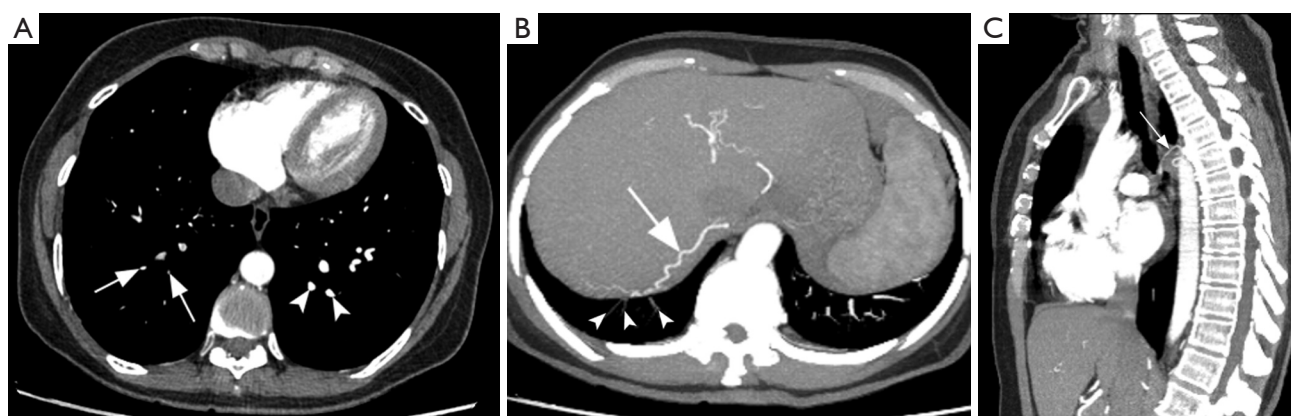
CT pulmonary angiography features of chronic thromboembolic pulmonary hypertension. Axial image (A) showing reduced caliber vessels (arrows) related to the contraction of the organizing thrombus and poor contrast opacification in comparison with contralateral arteries (arrowheads). Axial maximum intensity projection (MIP) at the thoracoabdominal transition (B) showing a prominent phrenic artery (arrow) providing systemic collateral circulation, in addition to asymmetric caliber of the pulmonary arteries in the lower lobes (attenuated on the right side, arrowheads). Sagittal MIP reconstruction (C) reveals a prominent bronchial artery providing systemic collateral circulation (arrow).
